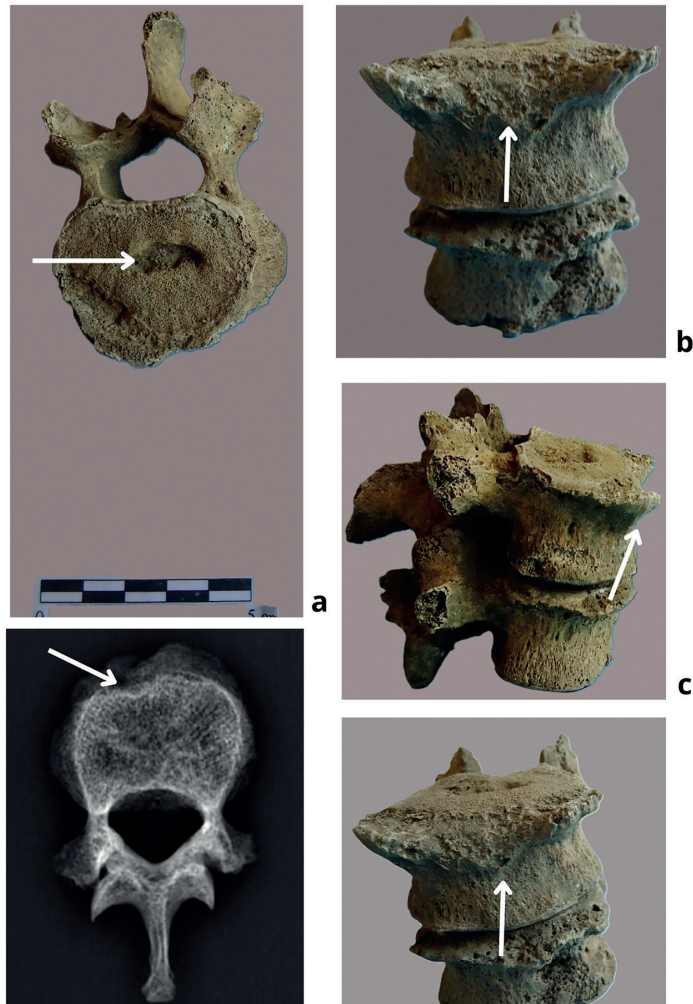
Schmorl's node on the vertebral body; Fig. 5b, c, d: Destructive osteolytic lesion involving the anterior spongy bone of the superior body of two thoracic vertebrae; Fig. 5e: Digital radiographic analysis which shows erosion in the upper-anterior portion of the vertebral body.
